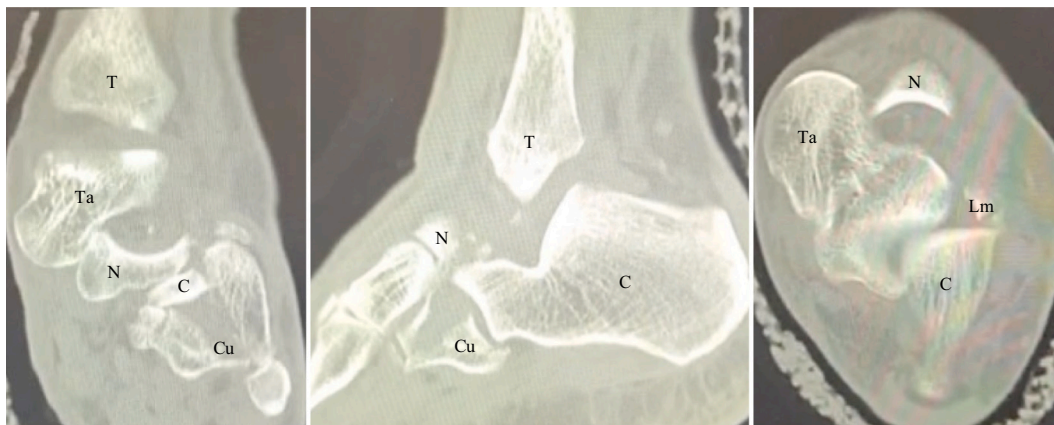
CT scan of the ankle and the foot confirmed the diagnosis but revealed a nutcracker cuboid fracture.
